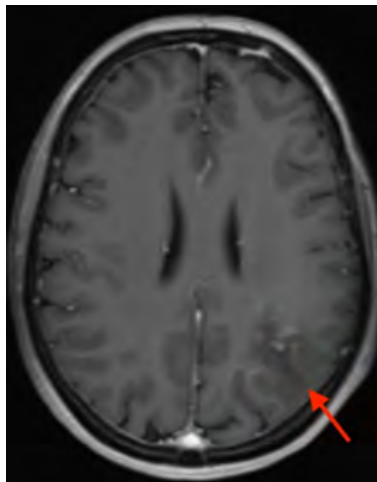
Axial contrast-enhanced T1-weighted magnetic resonance imaging (MRI) showing hypointense signal areas with patchy enhancement on the left parietal lobe.
